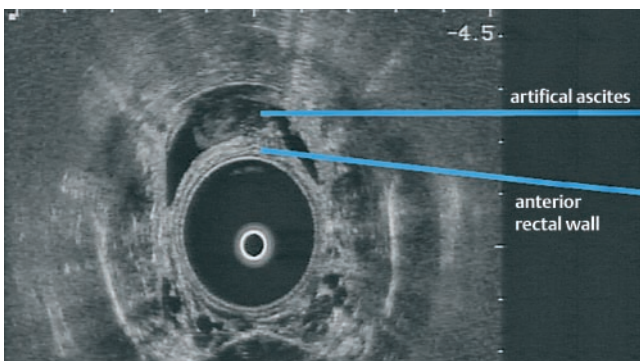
a The entry point is identified by transrectal ultrasound. At the height of the rectum, where fluid keeps the bowel loops apart, a safe access to the abdominal cavity should be possible. b The site formerly identified by transrectal ultrasound is encircled by a purse string suture (inset).
